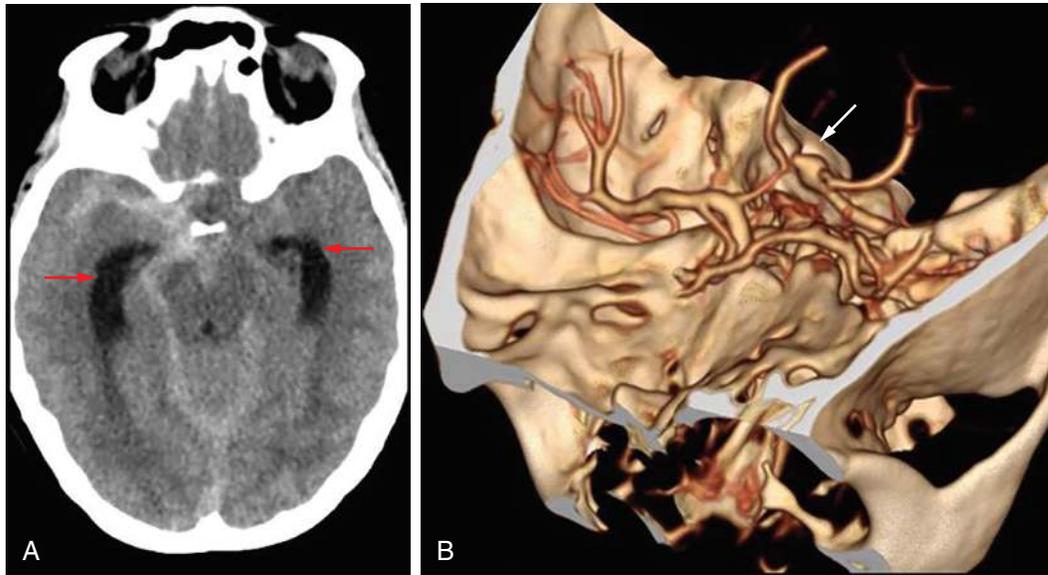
Aneurysmal subarachnoid hemorrhage. A, Noncontrast CT shows acute hyperdense subarachnoid hemorrhage filling the perimesencephalic cisterns and extending laterally into the right sylvian fissure. The temporal horns of the lateral ventricles are dilated (*red arrows*), representing acute hydrocephalus, which is a common complication of aneurysmal SAH. B, CTA in the same patient viewed using a volume-rendered reconstruction shows a complex saccular aneurysm arising from the tip of the basilar artery.
